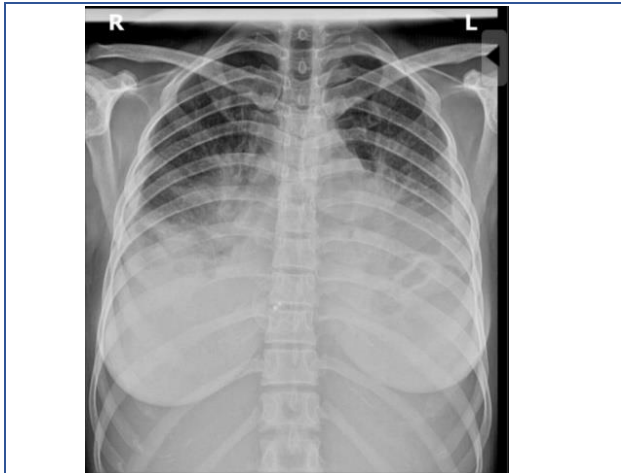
Chest X-ray showing bilateral pleural effusion with cardiomegaly
